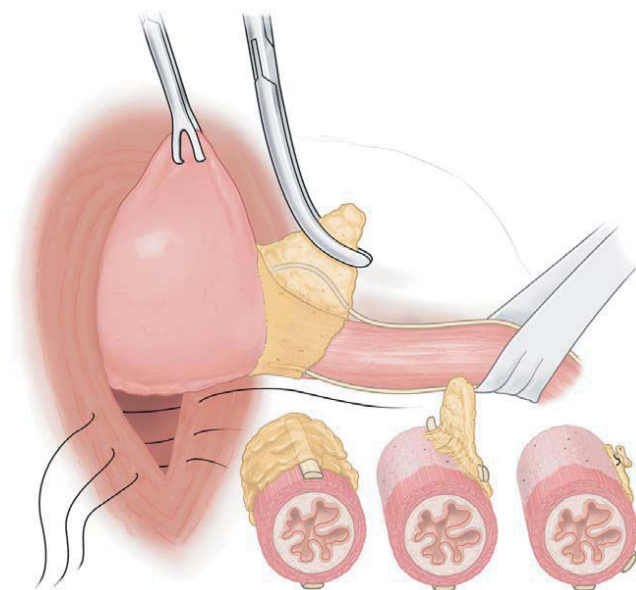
Transthoracic hiatal hernia repair. The anterior fat pad is removed from the esophagus with sharp dissection, with care taken to avoid injury to the vagi.
